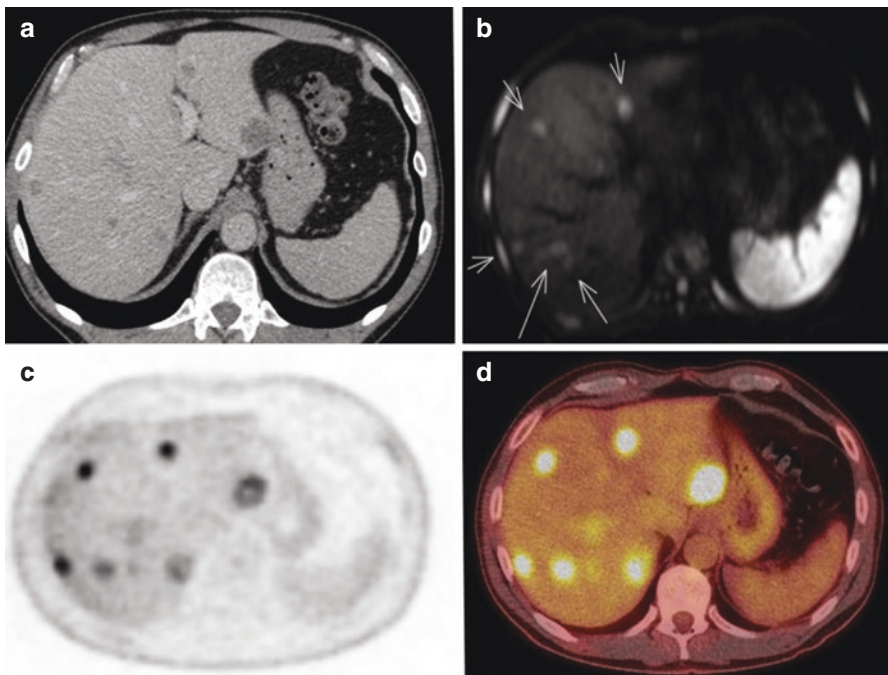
Comparison between different diagnostic modalities for colorectal liver metastasis. Clinical scenario of bilateral liver metastasis from colorectal cancer. (a) Contrast-enhanced computer tomography (CT). (b) Contrast-enhanced magnetic resonance (diffusion-weighted images). Arrows pointing metastatic deposits. (c) Functional study with fluorodeoxyglucose positron emission tomography (FDG-PET). (d) Combination of FDG-PET and CT (PET-CT)
